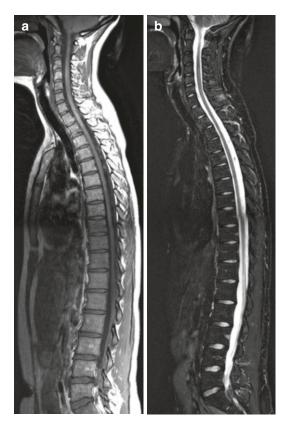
Normal MRI, spondylitis protocol with normal bone marrow signal intensity, (a) Sag T1 and (b) Sag STIR of the whole spine
